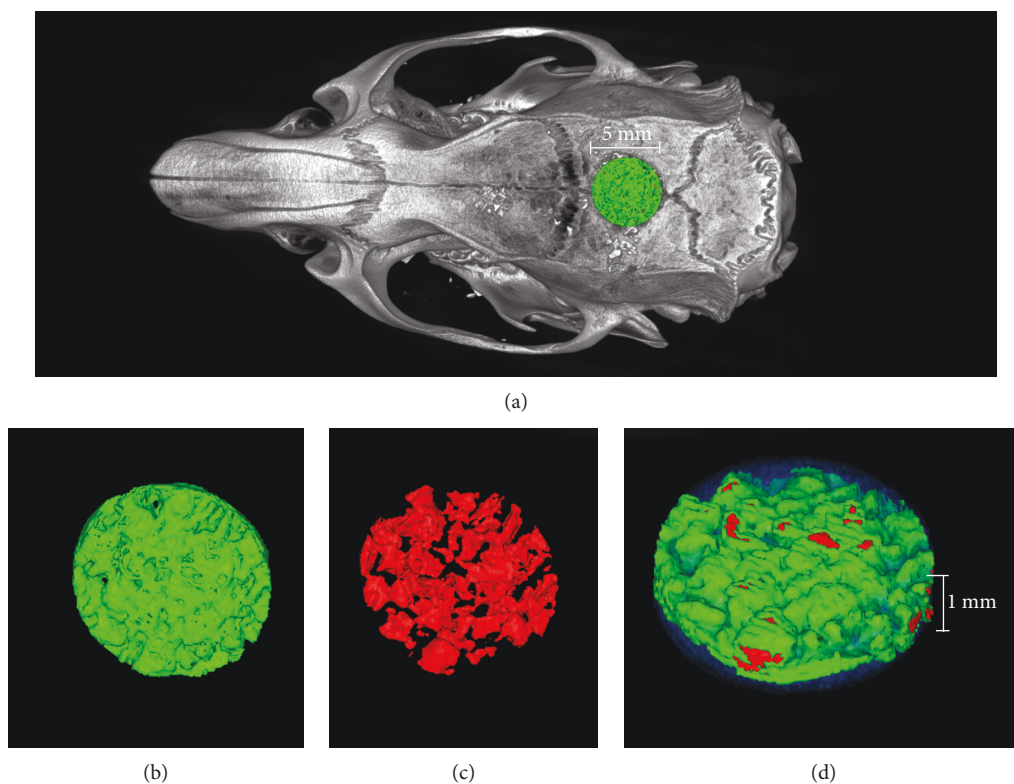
Definition of the region of interest (ROI). (a) The ROI was defined as a cylinder with a radius of 5 mm and a height of 1 mm from the surgery area. (b) Tissue with a CT value between 700 and 2000 Hu was defined as new bone; green=new bone. (c) Tissue with a CT value above 2000 Hu was defined as Bio-Oss® bone granules; red=bone granules. (d) Three-dimensional reconstruction of the ROI, translucent blue=CT value below 700 Hu.
